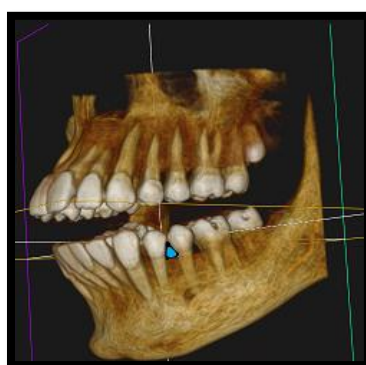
CBCT section showing bone defect.
